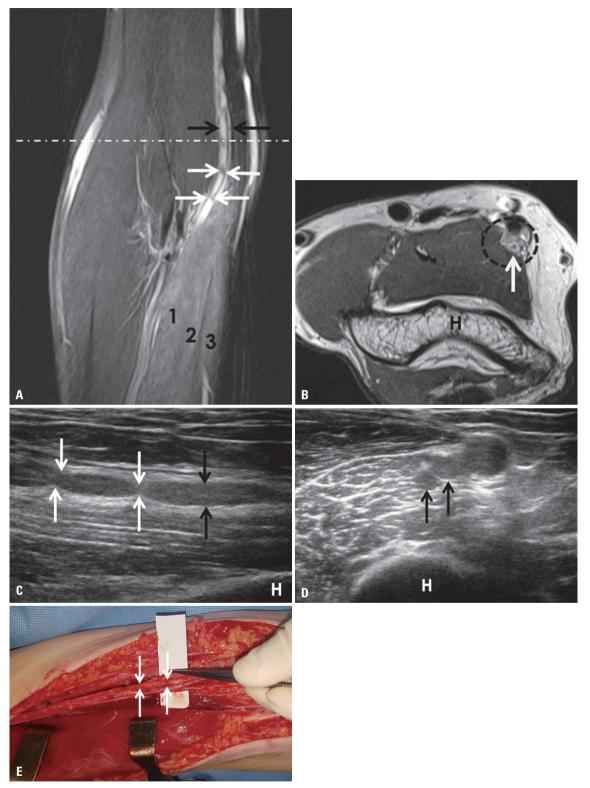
A 59-year-old man with hourglass-like constrictions and torsions of the dorsal fascicle of the right median nerve and pseudo-AIN syndrome. (A and B) Coronal FST2-weighted FSE image of the right distal arm to proximal forearm (A) shows multiple focal constrictions (white arrows) of the median nerve with uneven swelling (black arrows), in addition to high signal intensities in the pronator teres (1), the flexor carpi radialis (2), and the palmaris longus (3) muscles. Axial proton-weighted FSE image (B) obtained at a dashed line level (immediately above the constriction site) shows a peripheral hyperintensity and central hypointensity; bullseye sign (arrow) in the dorsal fascicle of the median nerve (dotted circle). (C and D) Longitudinal (C) and axial (D) ultrasonographic images of the median nerve at the distal upper arm level show fusiform swelling (black arrows) and hourglass-like constrictions and torsions (white arrows) of the fascicle of the median nerve. (E) On the surgical image of the median nerve at the distal upper arm and elbow levels, the dorsal fascicle of the median nerve shows multiple torsions (white arrows) above the elbow. AIN, anterior interosseous nerve; FS, fat-suppressed; FSE, fast spin echo; H, humerus.
